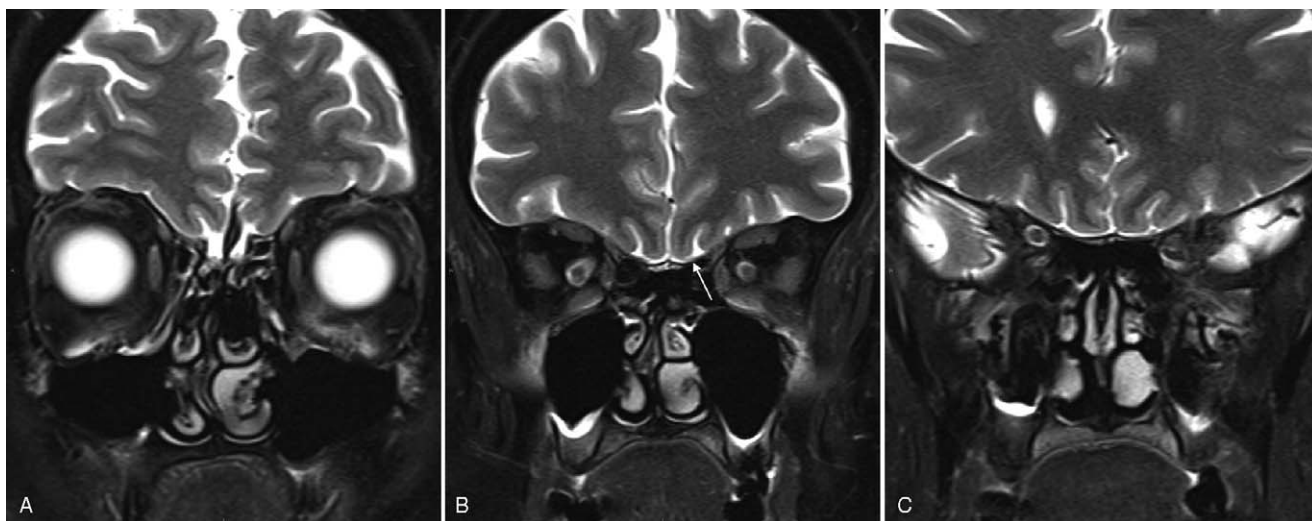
A–C, Coronal 3T MRI, T2 fat-saturated images with T2 hyperintensity left olfactory bulb (A) asymmetric T2 hyperintensity and enlargement left olfactory tract (B, C) (white arrow).
